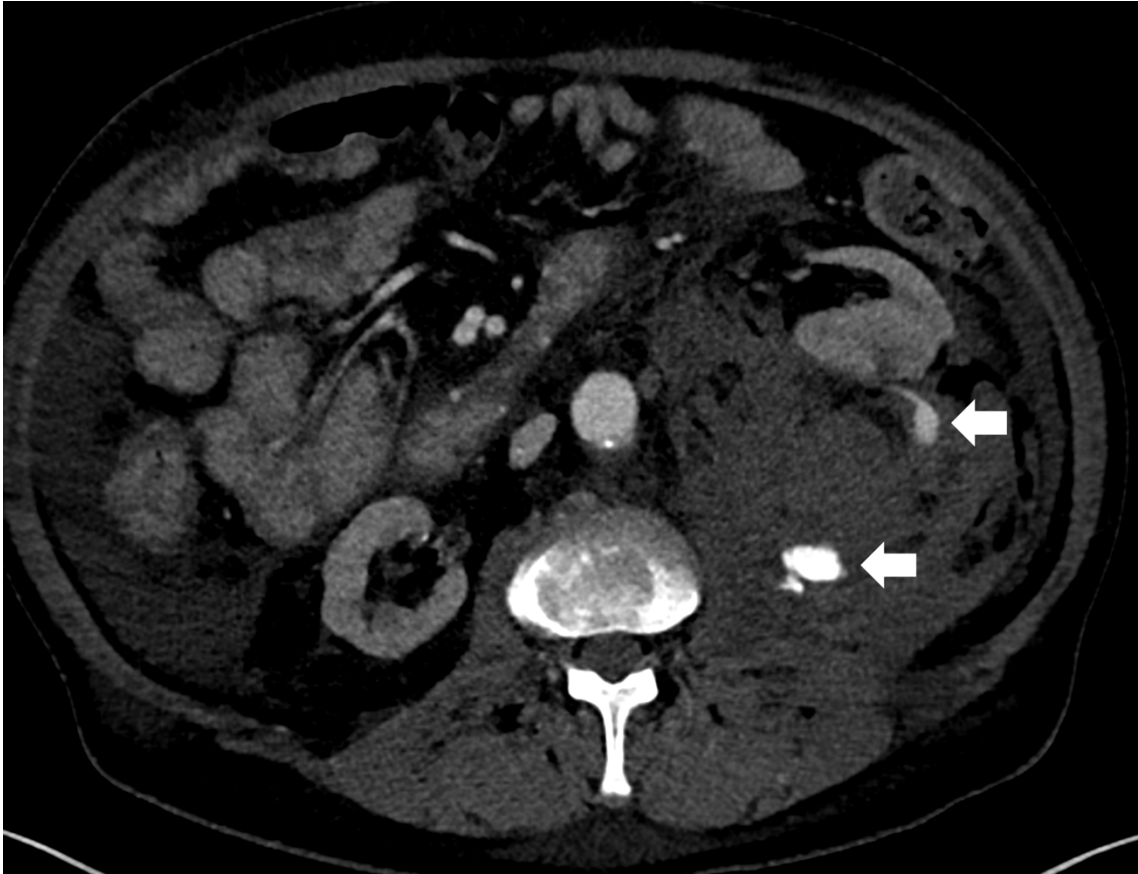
Active contrast extravasation in CT
